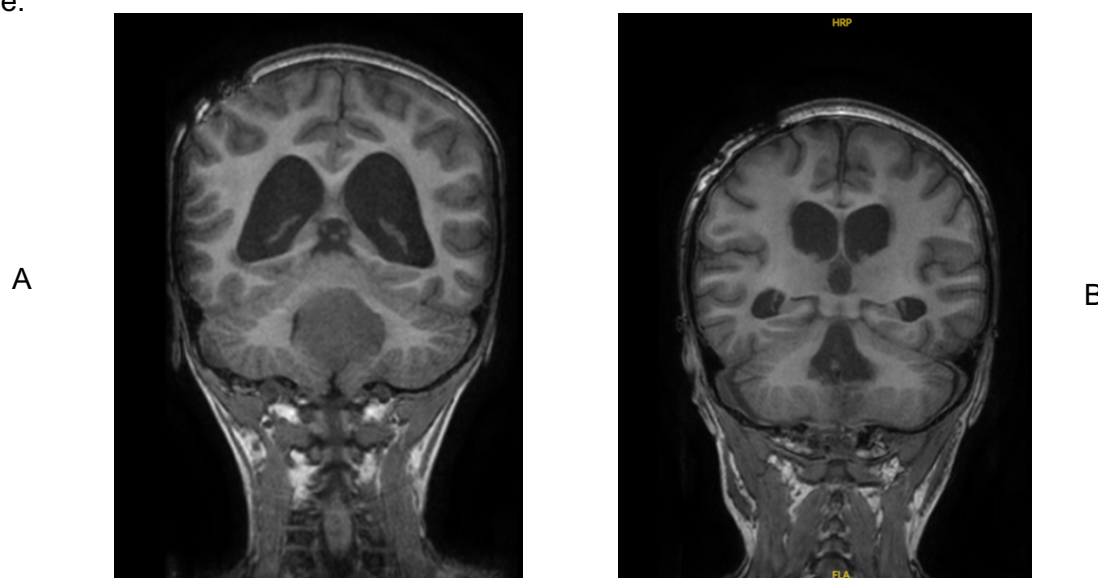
Child 3's pre- and postoperative MRI images of a midline cerebellar mass. (A) Preoperative scan showing the presence of the cerebellar mass in the midline region. (B) Postoperative scan demonstrating complete removal of the mass
